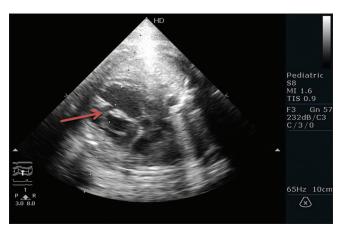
Fetal echocardiogram arrow showing two-dimensional image of mid-muscular ventricular septal defect
